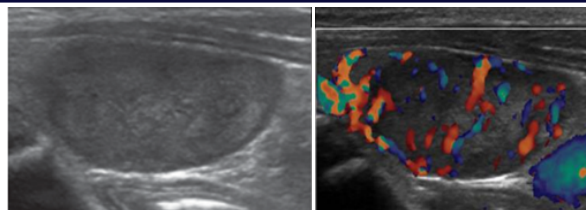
HRUSG neck : Evidence of left parathyroid adenoma noted with increased perilesional and intralesional vascularity on colour doppler study.
